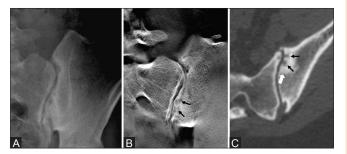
(A-C): Standard radiography of the left sacroiliac joint. (A) No bony erosion could be detected (B) Tomosynthesis (coronal plane) and (C) CT scan (axial plane) examination discloses subtle subchondral erosions of the sacroiliac joints (arrows), whereas bone sclerosis (large arrow) is depicted on standard CT scan
